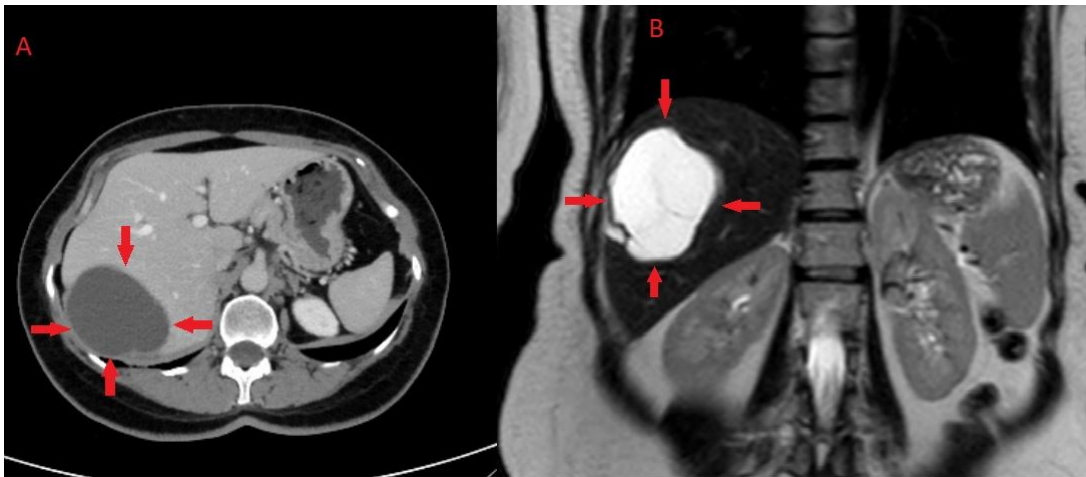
Image of cystic lesion in the liver by computed tomography(A) and magnetic resonance imaging(B).
